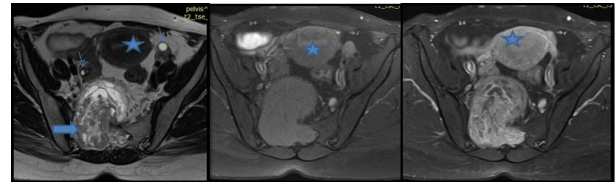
MRI pelvis - T2W, T1W and post contrast T1W axial images showing large heterogeneously enhancing lesion (thick arrow) in the spinal canal extending into presacral region through widened right neural foramina suggestive of neurogenic tumour. normal appearing uterus and ovaries (thin arrow) are seen separately
